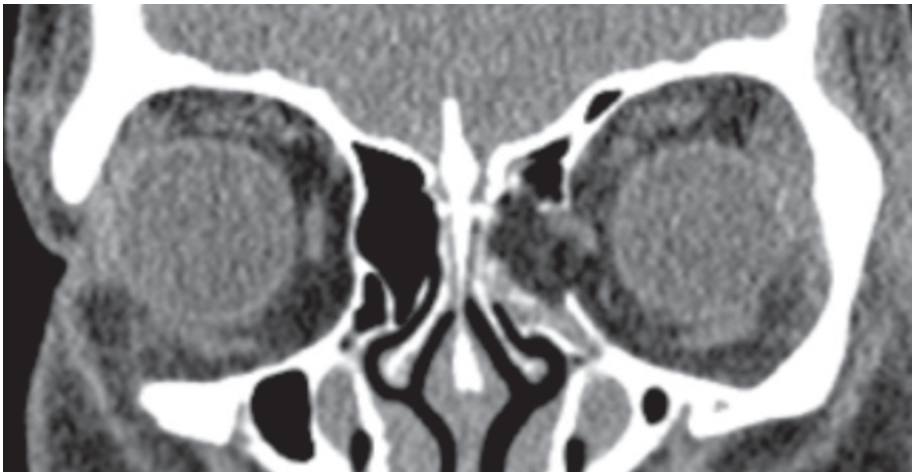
CT scan of a patient with BOF in left orbit with limitation to adduct the left eye was observed 7 days after the injury. This patient was considered to have impingement of left medial rectus muscle.
